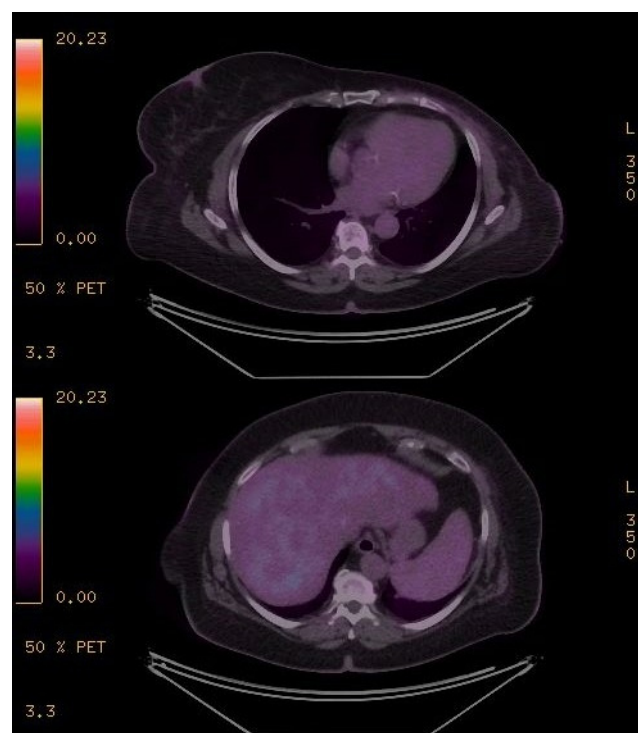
Axial PET/CT slices postleft mastectomy and right sentinel lymph node biopsy, showing no evidence of distant metastases. PET/CT, positron emission tomography/CT.
